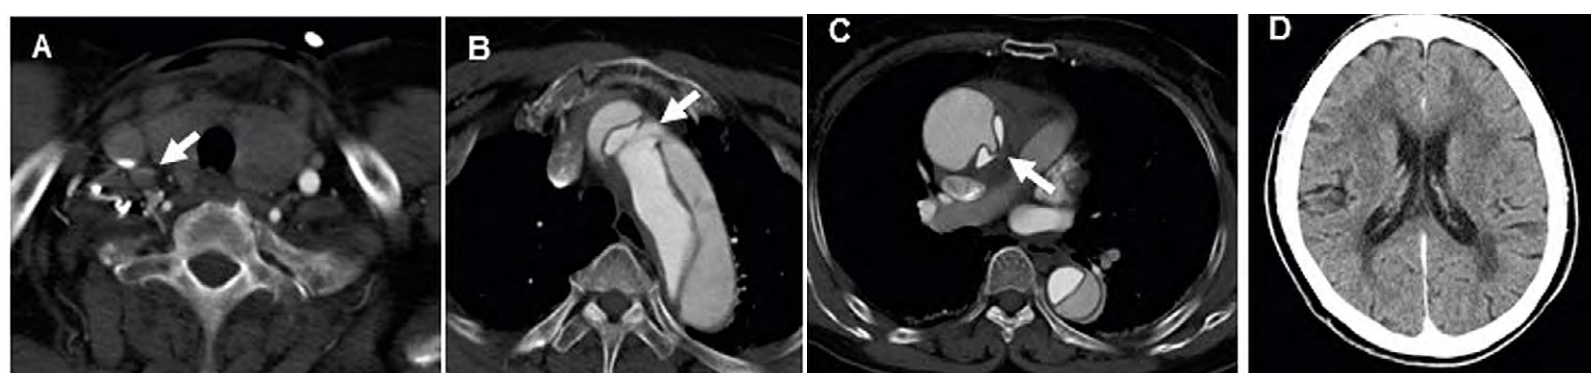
Preoperative enhanced CT scan of the thorax (A–C) and a plain CT scan of the brain (D) in a representative case. A. Occluded right common carotid artery (arrow). B. Intimal tear in the aortic arch (arrow). C. Compressed true lumen of the ascending aorta (arrow). D. A preoperative brain CT scan showed no ischaemic findings.
